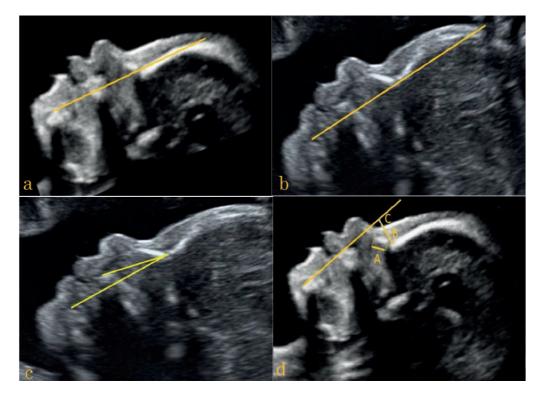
Ultrasound images of the markers in DS fetuses. (a) FP line position 'zero'; (b) FP line position 'positive'; (c) MNM angle; (d) NBL (A), PT (B), PT-NBL ratio (B/A), PFSR (C/B). FP, fetal profile line; MNM angle, maxilla-nasion-mandibula angle; NBL, nasal bone length; PT, prenasal thickness; PT-NBL ratio, prenasal thickness to nasal bone length ratio; PFSR, prefrontal space ratio.
